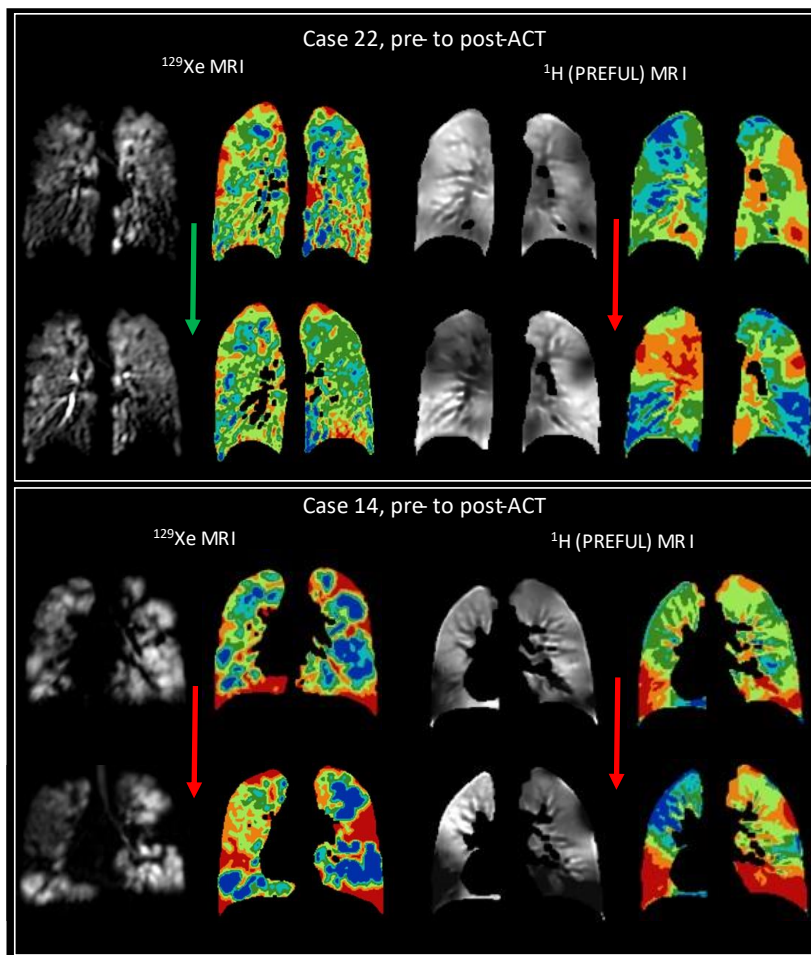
Comparison of ^{129}Xe and ^1H (PREFUL) for two cases, for each case raw ^{129}Xe MRI and ^1H (PREFUL) images are shown with their corresponding ventilation binning map. In Case 22 there was divergence; ^{129}Xe VDP significantly reduced but ^1H VDP significantly increased. In Case 14 there was agreement; both ^{129}Xe and H VDP significantly increase.
